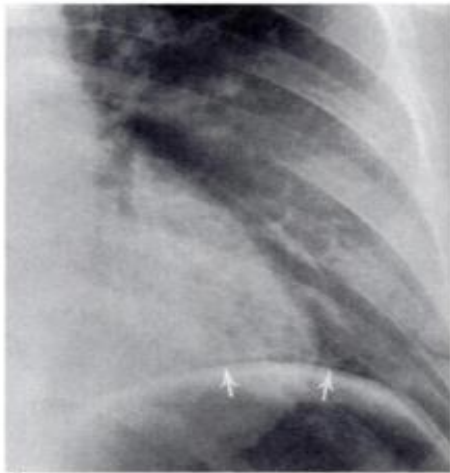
Pneumomediastinum from asthma. The radiograph shows gas (arrows) extending from the mediastinum and separating the pleura (parietal and visceral layers) from the diaphragm. This finding is known as the extrapleural sign.^{1,2}
